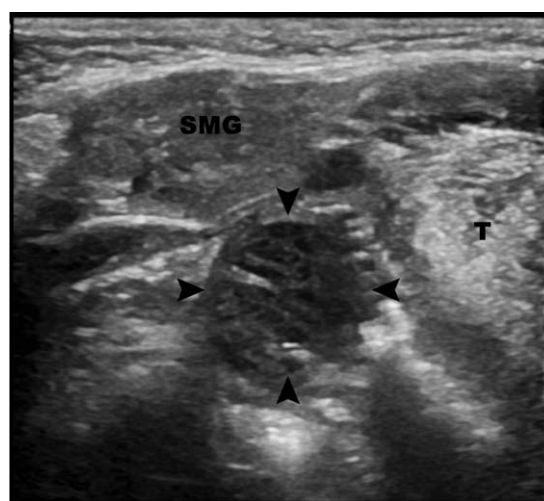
Example of a normal transcervical ultrasound of the tonsil and peritonsillar region. The tonsil has a striated appearance and is outlined by the black arrow heads. SMG = submandibular gland; T = tongue.
